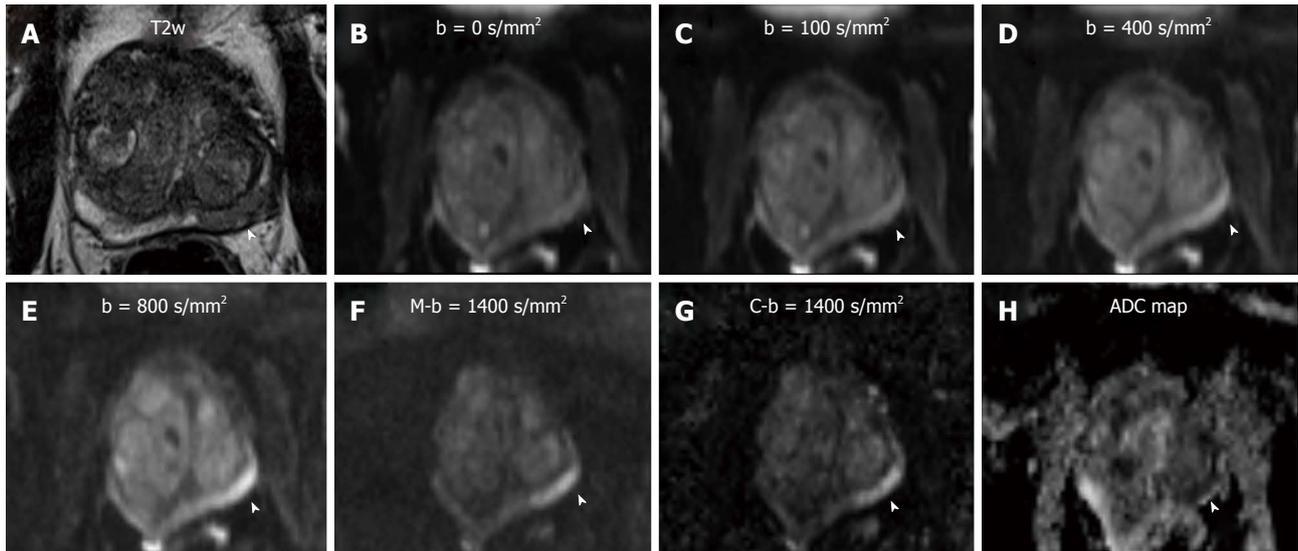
Axial T2-weighted image of an 88 years old patient with a PSA level of 8.2 ng/mL and negative findings upon digital rectal examination. T2w shows a focal hypointense lesion in the posterolateral left midgland pz (arrowhead in A). Measured b-values of 0, 100, 400 and 800 s/mm² (arrowheads in B, C, D and E, respectively) do not depict the suspected lesion with sufficient contrast to background prostate. M-b1400 shows good lesion-to-prostate contrast (arrowhead in F). C-b1400 depicts the lesion with the same lesion-to-prostate contrast and a slightly improved demarcation (arrowhead in G). The ADC value of the suspicious lesion was as low as $648 \times 10^{-3} \text{ mm}^2/\text{s}$ [ADC map (H)].
